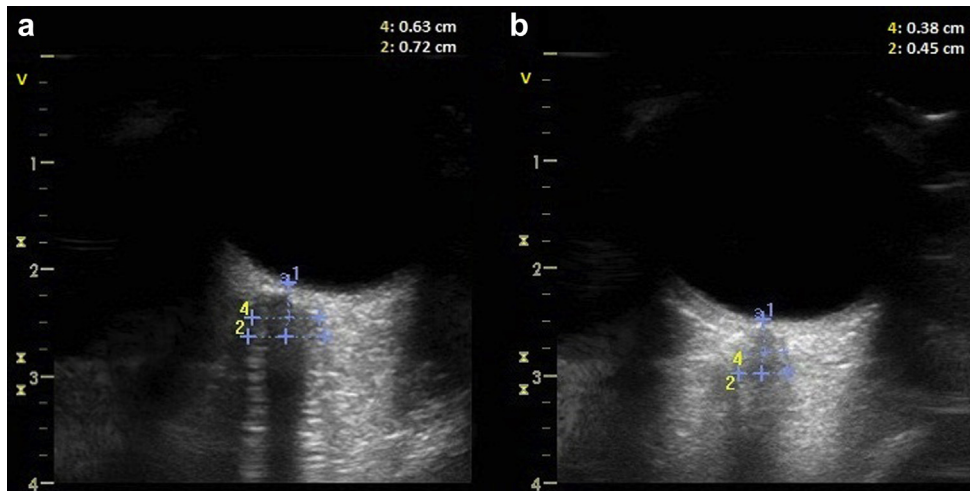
Transbulbar B-mode sonography of the optic nerve sheath diameter (ONSD) of a healthy subject (a) compared with that of a patient with multiple sclerosis (b). The distance between the external borders of the hyper-echoic area surrounding the optic nerve was quantified as ONSD. Lines 4 and 2 indicate ONSD at 3 and 5 mm from the eyeball, respectively. Note the smaller size of the ONSD in the patient with multiple sclerosis at both 3 and 5 mm from the eyeball.
